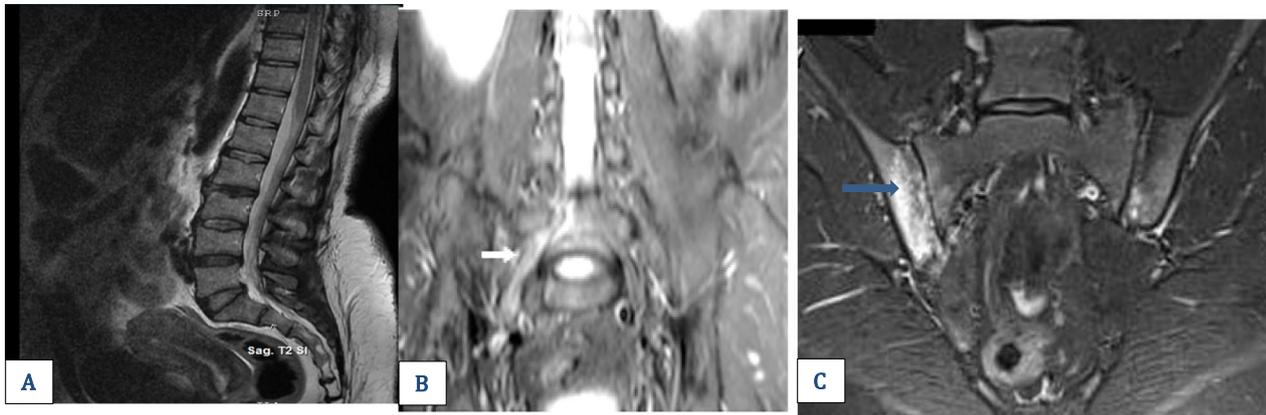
A 45-year-old female patient (a known case of seronegative arthropathy), presented clinically with severe right sciatic pain referred to the right buttock and thigh with numbness and weakness. Electrophysiological studies showed prolonged F wave latency, +ve ipsilateral straight leg raising test. Sagittal LS MRI shows no significant disk lesions (A). Pelvic MRN shows thickened and high signals in the right sciatic nerve with bilateral sacro-iliitis, more on the right side (Arrows in B and C)
